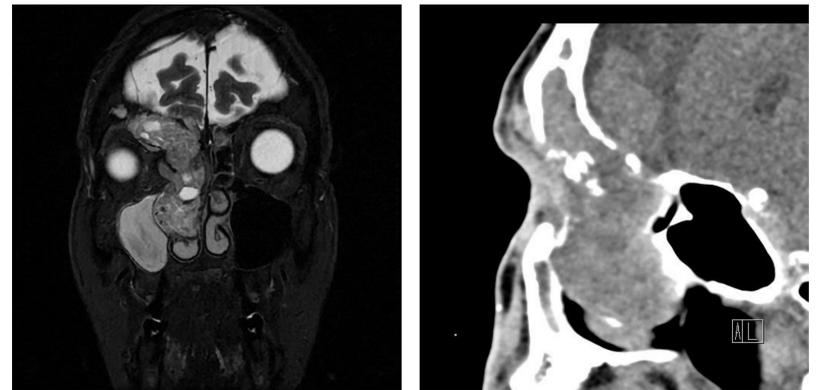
CT orbits MRI of the patient after first consult with ENT practitioner
